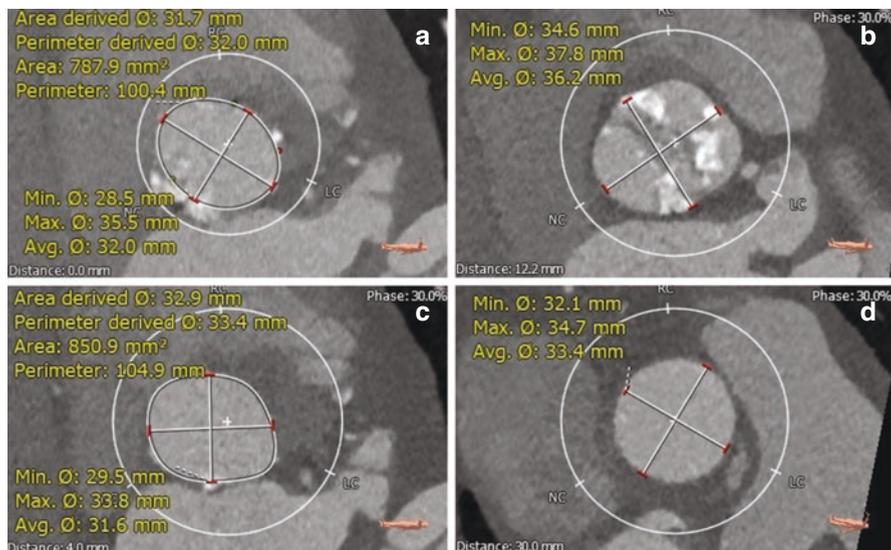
Reconstructed CT images. (a) Bicuspid AV area of 787 mm² and a 100.4 mm perimeter. (b) The left and right coronary cusps are fused by calcified raphe. (c) The LVOT area is 850 mm². (d) Sinotubular junction area is 850 mm²
